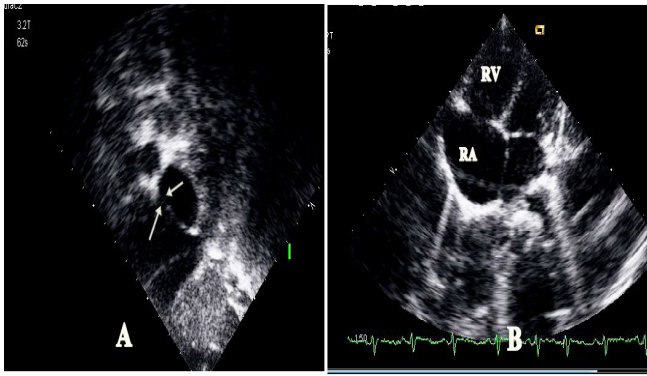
A-2D Echocardiography with subcostal bicaval view showing 5 mm sinus venosus atrial septal defect [arrow mark]. (SV ASD- sinus venosus atrial septal defect), B- apical 4 chamber views showing right atrial (RA) and right ventricular (RV) dilatation
